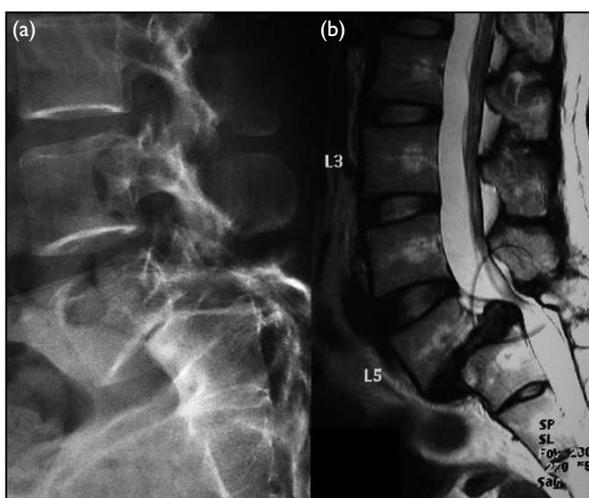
(a) Lateral X-ray and (b) T2-weighted magnetic resonance images showing severe spondylolisthesis and spinal stenosis
